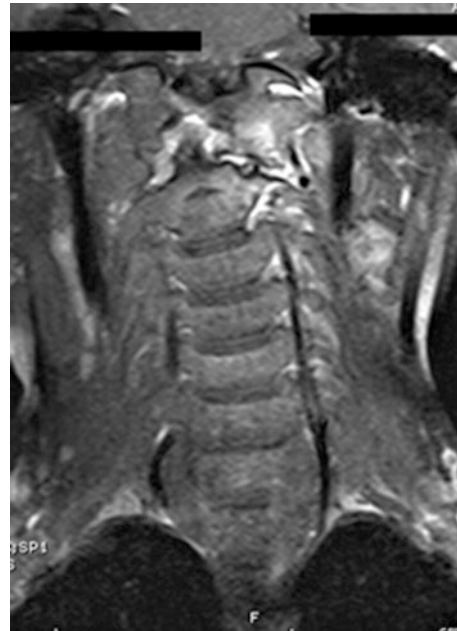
MRI of the patient with JRA shown in Fig. 3.1 depicting the synovitis and erosive nature of the disease process
